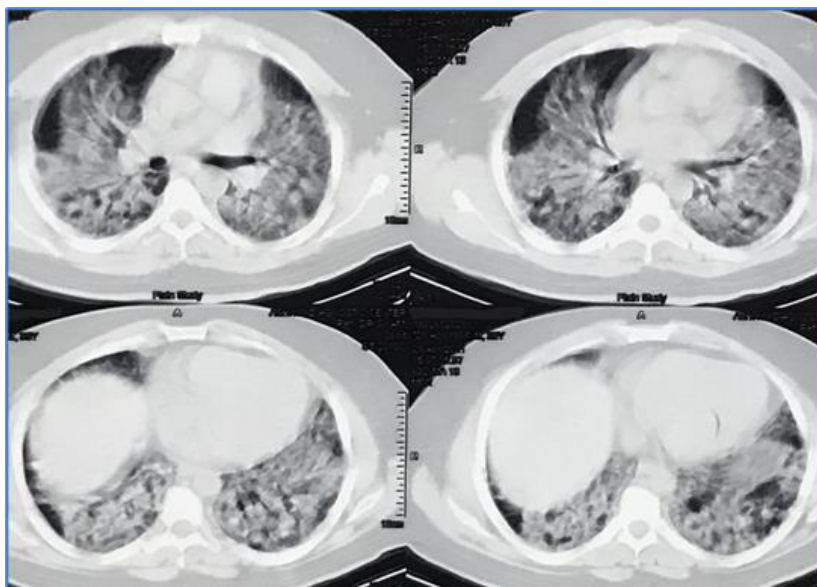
HRCT thorax showing bilateral GGOs and consolidations in middle and lower lobes
